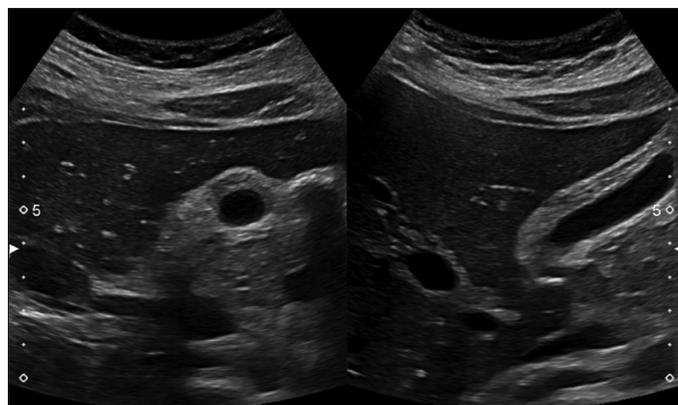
Abdominal ultrasound. Transverse and longitudinal sections using a curvilinear transducer demonstrate significant and diffuse echogenic gallbladder wall thickness along with edematous changes. No shadowing of gall bladder calculus or echogenic sludge was noted.
